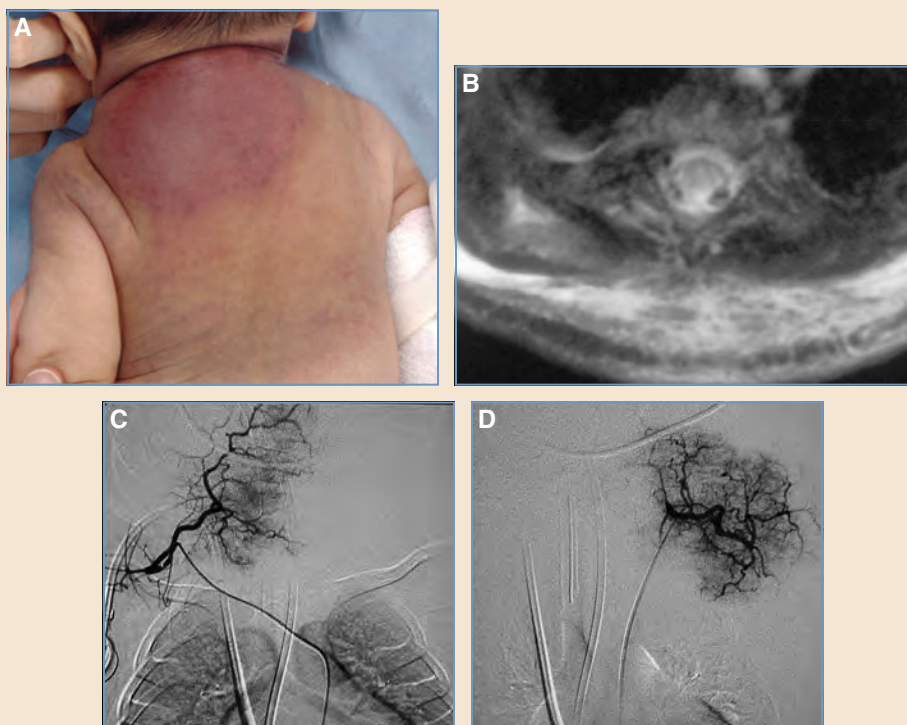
KHE. A, Typical appearance of KHE with violaceous tumor. B, MRI (T2-weighted sequence) shows a hyperintense soft tissue tumor with typical subcutaneous stranding from dilated subdermal lymphatics. C and D, Selective microcatheter angiography shows typical hypervascular tumor with no shunting.
